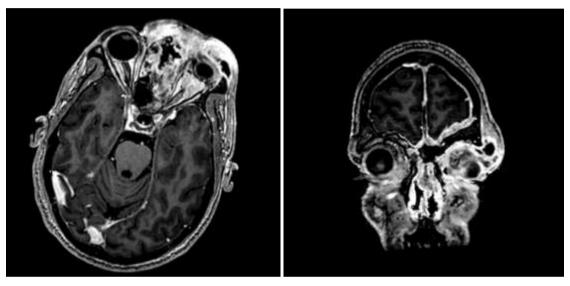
MRI depiction of orbital invasion in rhino-orbital mucormycosis, highlighting medial rectus muscle thickening and optic neuritis
